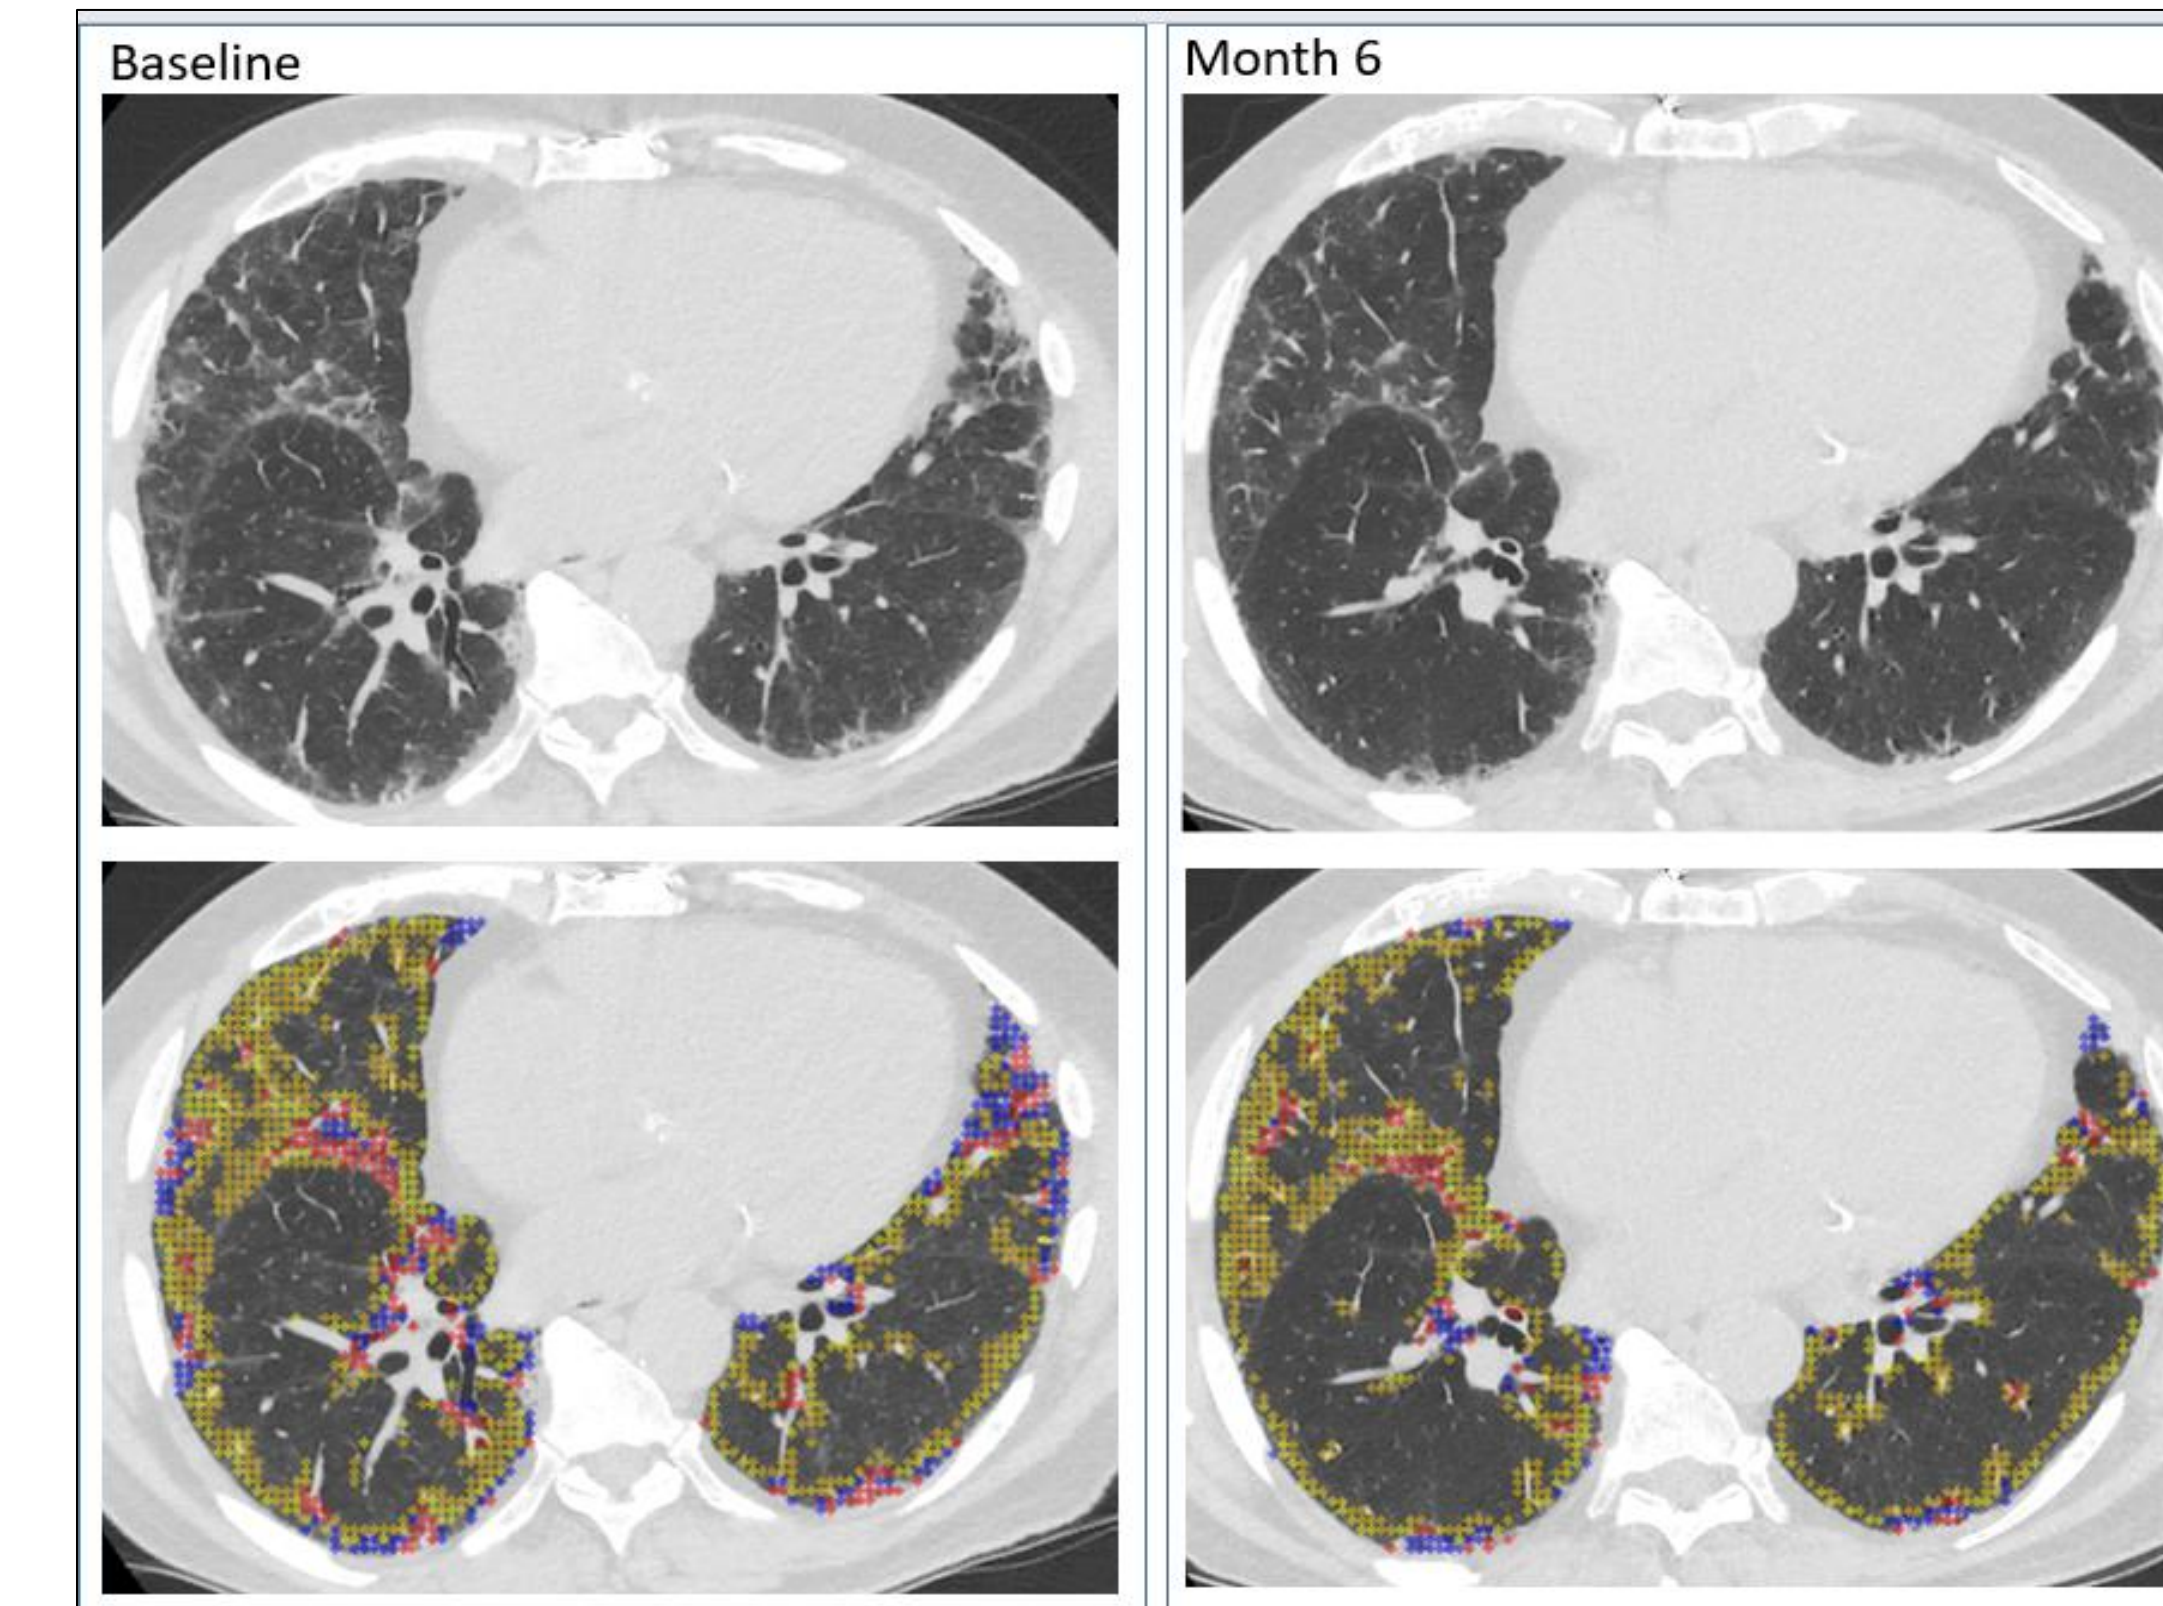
SuperResponder examples. Axial HRCT images and overlaid quantitative results with the blue and red dots indicating the results of QLF classification and the yellow dots indicating the ground glass.
